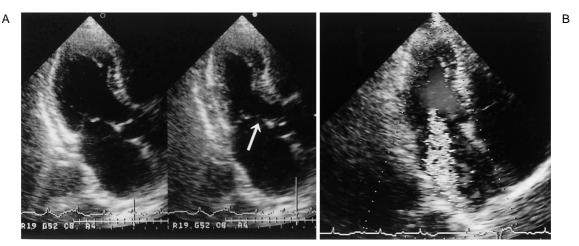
Initial echocardiographic examinations
